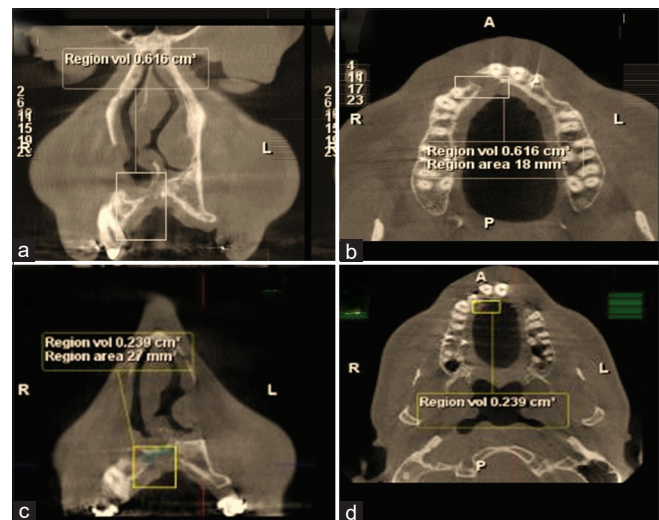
Cone beam computed tomography images of a 10-year-old male patient who underwent unilateral alveolar cleft surgery using fibrin glue. (a and b) the coronal and axial cuts before surgery and (c and d) the coronal and axial cuts after surgery, respectively.
